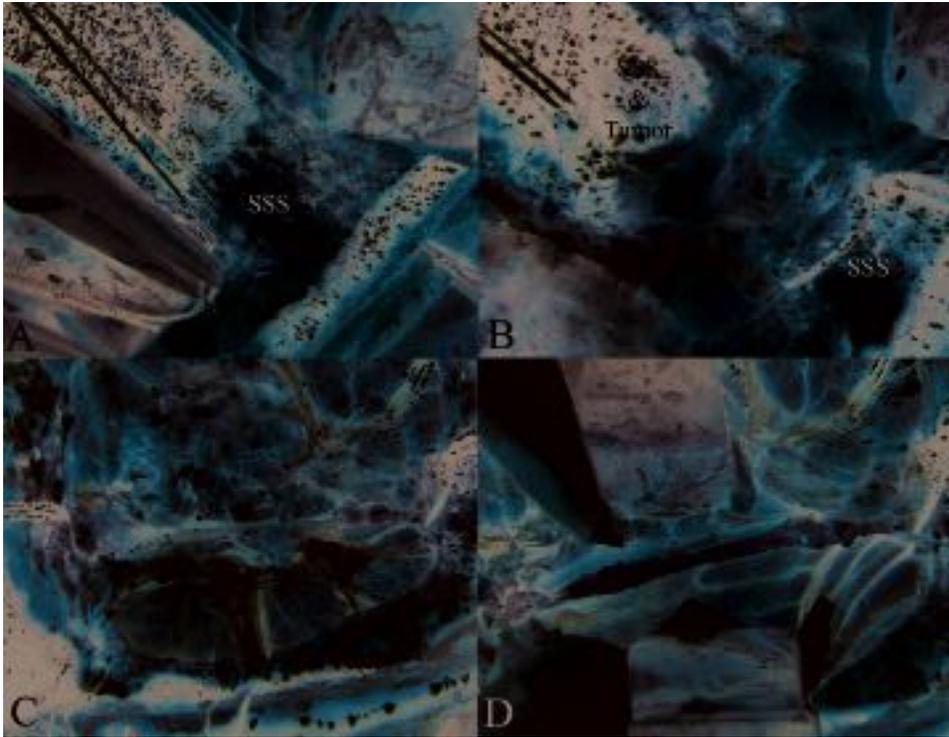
A 63-year-old woman with a history of recent onset of intracranial hypertension and left-sided hyposthenia. Magnetic resonance imaging showed a right-sided parasagittal meningioma with complete occlusion of the superior sagittal sinus (SSS). (A) A silk suture is placed across the falx just distal to the proximal end of the tumor-encased portion of the SSS. (B) The sinus has been ligated and cut. (C) The sinus has been ligated and cut at the proximal and distal ends of its involvement within the tumor. (D) A self-retracting spatula helps to visualize the resected margin of the falx and the two ends of the resected sinus.
